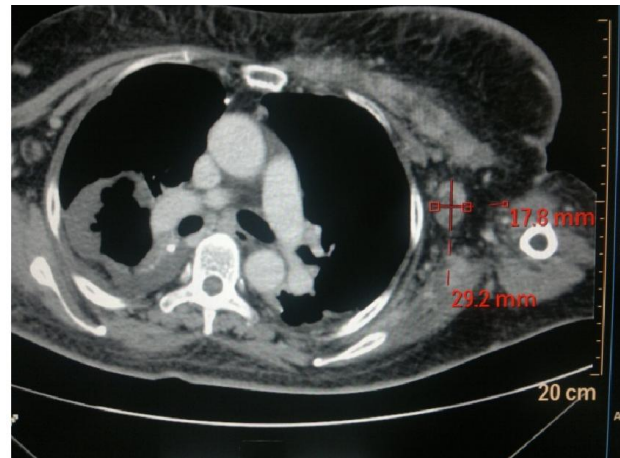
CT chest showing solitary left axillary lymph node measuring $29 \times 17\text{mm}^2$
